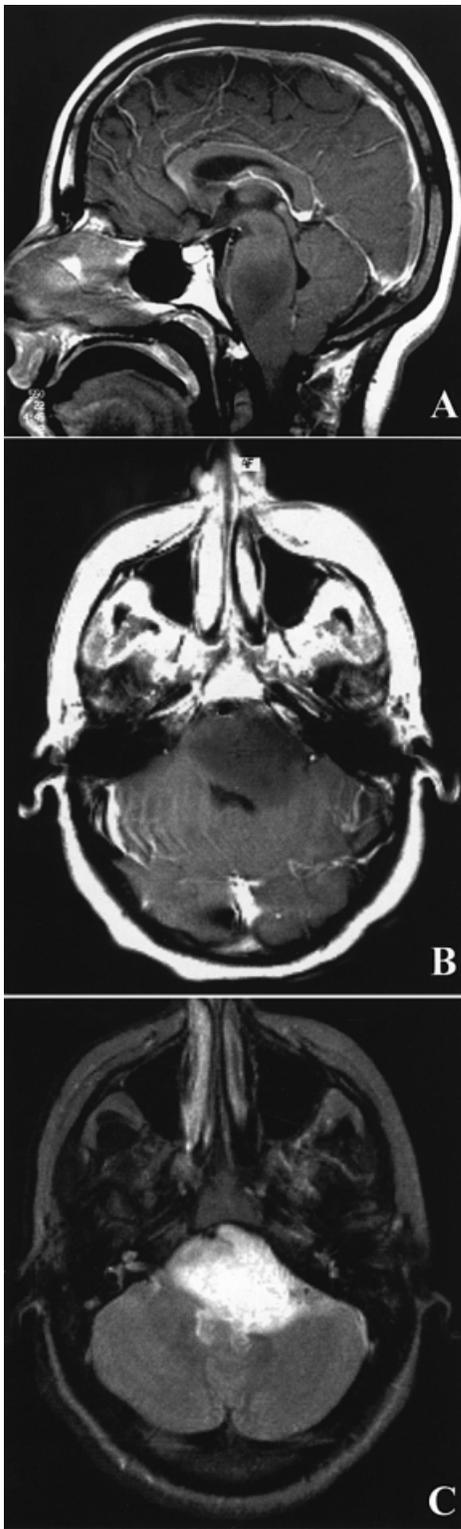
MRI of a patient with non-enhancing, diffusely infiltrative tumour classified as an intrinsic diffuse low-grade brainstem glioma. (A) Sagittal T₁-weighted image after gadolinium infusion. (B) Axial T₁-weighted image after gadolinium infusion. (C) Axial T₂-weighted image.
